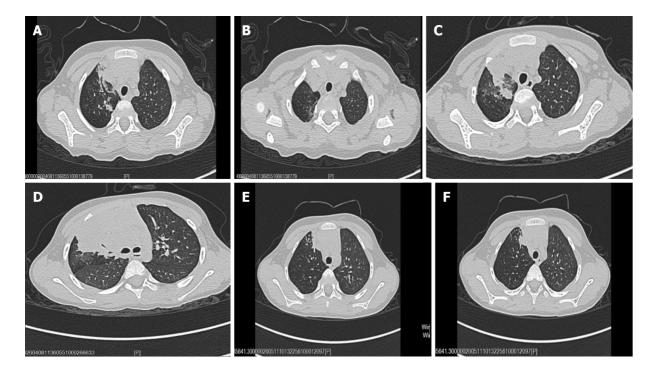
Radiological findings. A and B: Chest computed tomography (CT) images showing right upper lobe pneumonia with segmental atelectasis; C and D: Chest CT images showing that the inflammatory lesions of the right upper lung were expanded and new lesions appeared in the right lower lung; E and F: Chest CT images showing that the inflammatory lesions were diminished and the atelectasis was partially restored.
